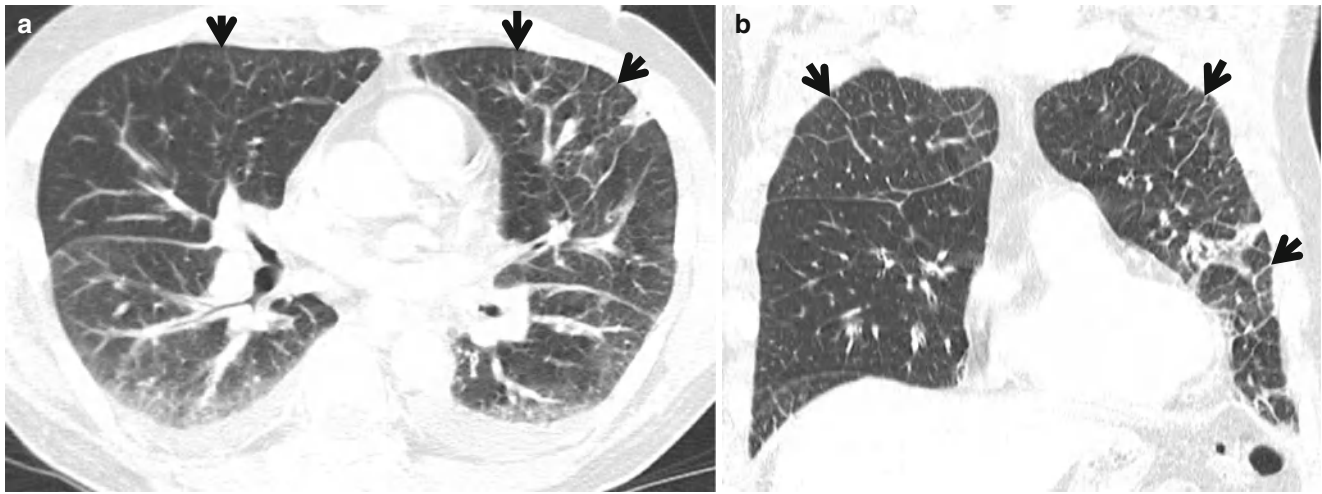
Acute eosinophilic pneumonia in a 57-year-old man. Patient complains of cough and sputum. (a) Lung window of CT scan (5.0-mm section thickness) obtained at level of right middle lobar bronchus shows subpleural areas of ground-glass opacity particularly in posterior
